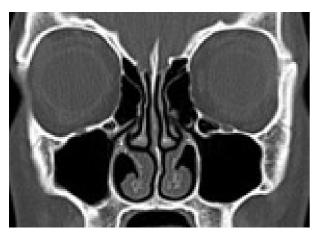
(a): CT scan of normal sinuses full of air (sinuses are black).
